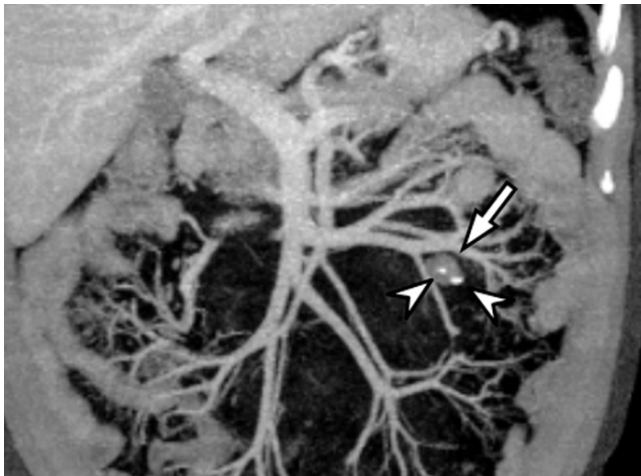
Mesenteric hemangioma in 47-year-old male. On coronal, maximum-intensity projection CT image, small, round, soft tissue lesion is found in left-sided small bowel mesentery (arrow). Two small punctate calcifications (arrowheads) are seen within lesion. After mass excision, this lesion was confirmed as being mesenteric hemangioma.
